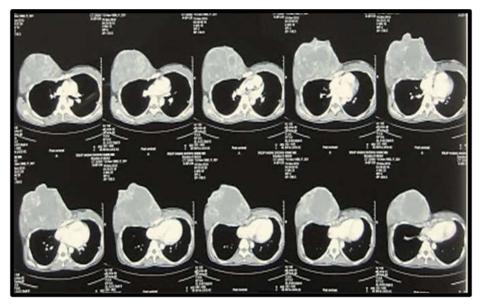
CT scan of the chest with contrast.
